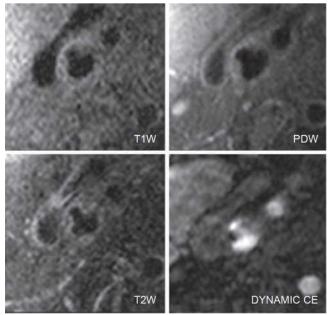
Multicontrast MR images show a large surface ulceration in a carotid artery plaque. (Modified from Chu B, Ferguson MS, Chen H, et al: Cardiac magnetic resonance features of the disruption-prone and the disrupted carotid plaque. JACC Cardiovasc Imaging 2:883, 2009.)
